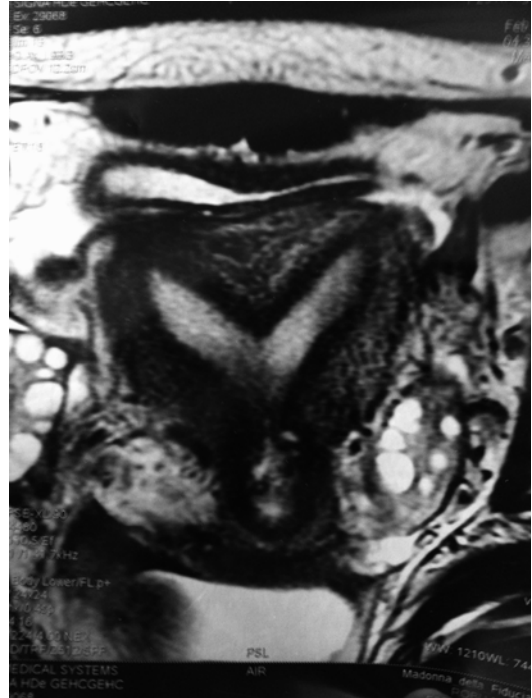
MRI image of a partial septate uterus (ESHRE/ESGE Class U2a)
